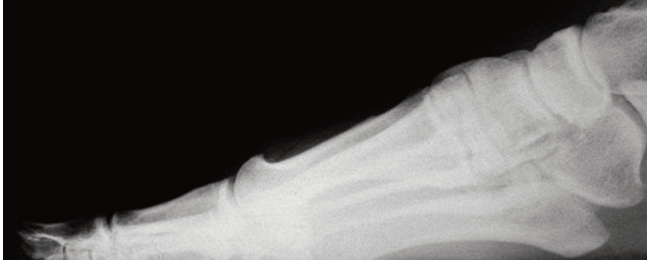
Radiographic appearance of distal first metatarsal elevation. Note the first metatarsal dorsiflexion relative to the second metatarsal. Both the hypermobile and stable PFR may exhibit these clinical findings and are indicative of functional or structural hallux limitus. The symptoms of joint limitus may be generated by medial column overload necessitating treatment via orthotics postoperatively. Cheilectomy and other procedures may be indicated in addition to hallux valgus repair.
